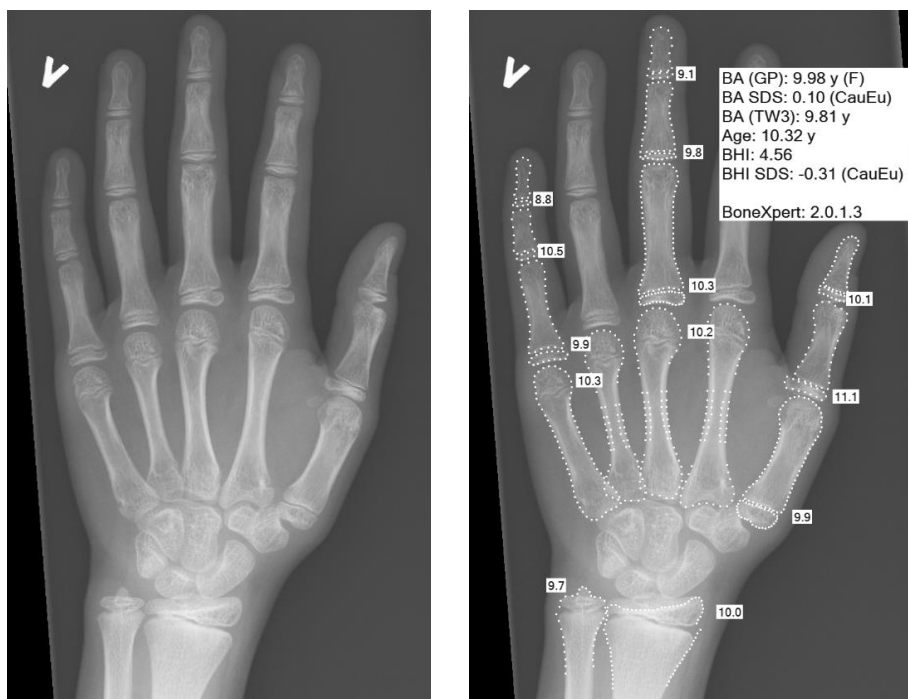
Radiograph of the left hand in a 11-year-old girl, using an automated bone-age analysis tool (BoneXpert).
